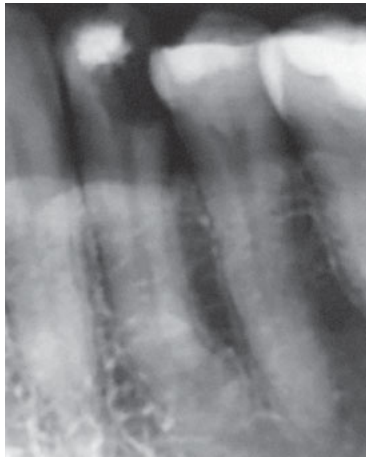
Preoperative radiograph of tooth 34.
